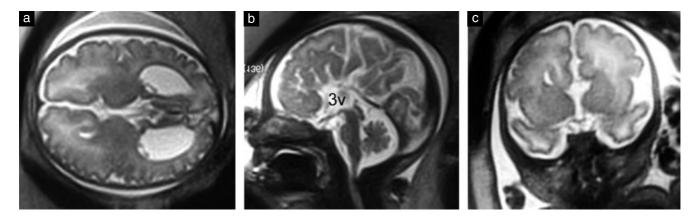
Magnetic resonance imaging (MRI) of agenesis of the corpus callosum in a third-trimester fetus: (a) axial, (b) mid-sagittal and (c) coronal views. Apart from demonstrating the absence of the corpus callosum, MRI has the advantage of clearly showing the normality of the convolutional pattern, a finding that has a major impact on prognosis. Notice the radial arrangement of the gyri around the roof of the third ventricle (3v).
